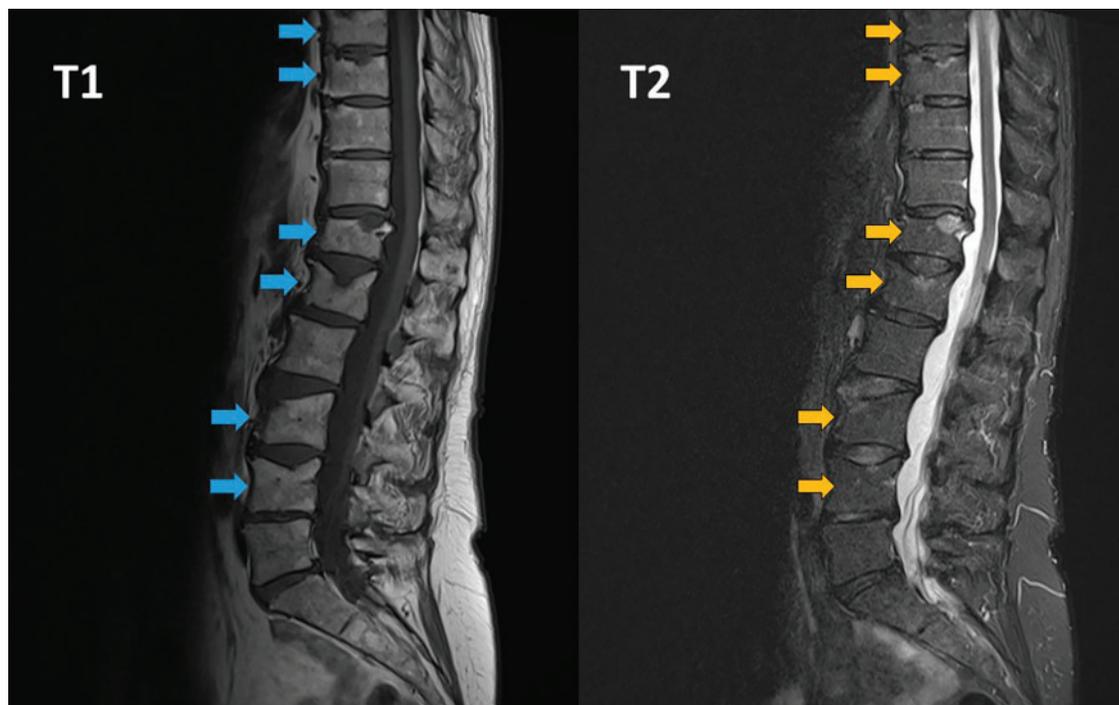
T1-weighted magnetic resonance imaging (left) indicated vertebral fractures of T8, T9, T12, L1, L3, and L4 (arrows). T2-weighting (right) showed bone marrow edema (arrows).
